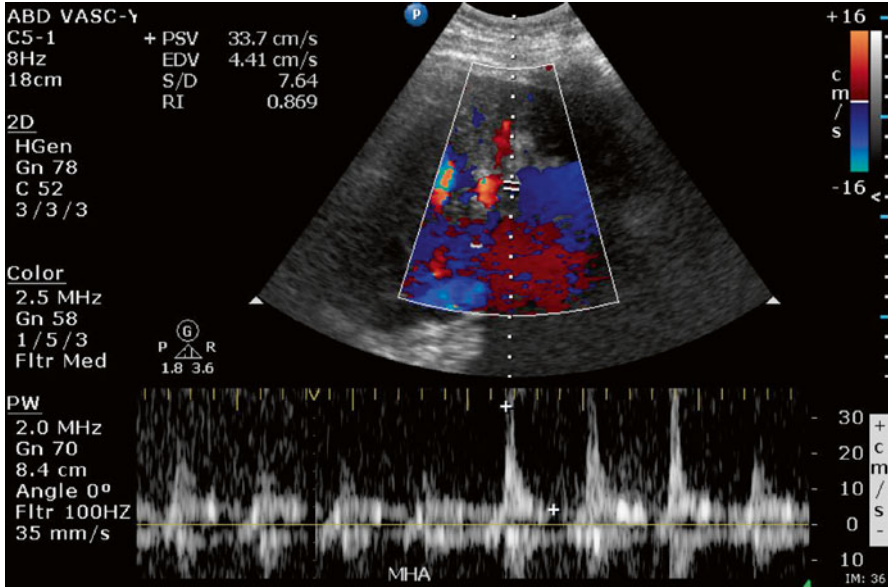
This Color Doppler study of a 48-year-old man who underwent orthotopic liver transplantation shows decreased diastolic flow and high resistive index in the main hepatic artery. Further follow up demonstrated rising intraabdominal pressure secondary to hemoperitoneum
